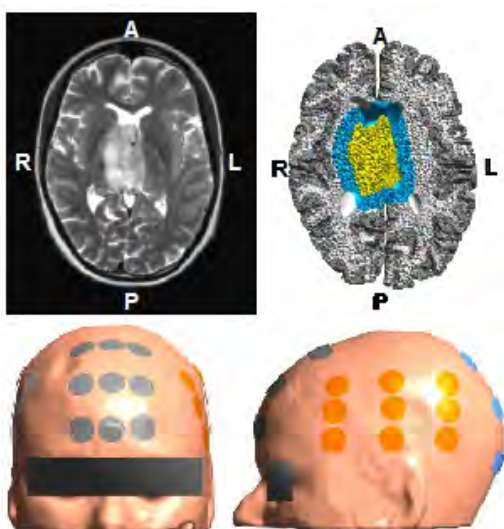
Example of patient specific head model based on MRI data. The figure shows an axial T2 MRI image (left) obtained from a 23 year-old female patient with deeply seated anaplastic astrocytoma. The three rightmost panels show the head model and tissue segmentation, which was created from the MRI data (T1 and T2) from the same patient. Electrode positioning is evident from the surface reconstruction and electrodes are paired orange/white (LR) and gray/blue (AP).
